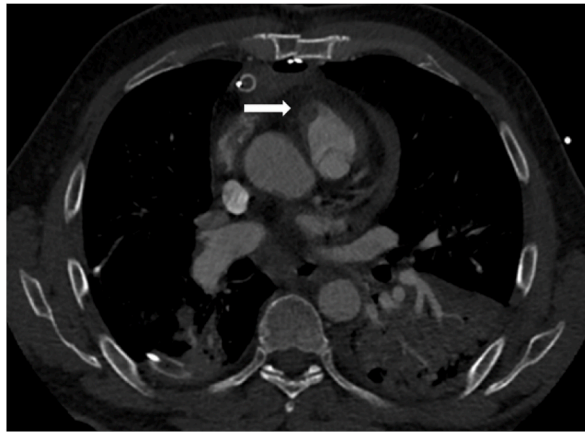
CTA image shows the presence of a pulmonary endoluminal filling defect localized in the proximal portion of the common pulmonary trunk affecting the valve plane too (white arrow), a rare localization in PE.
